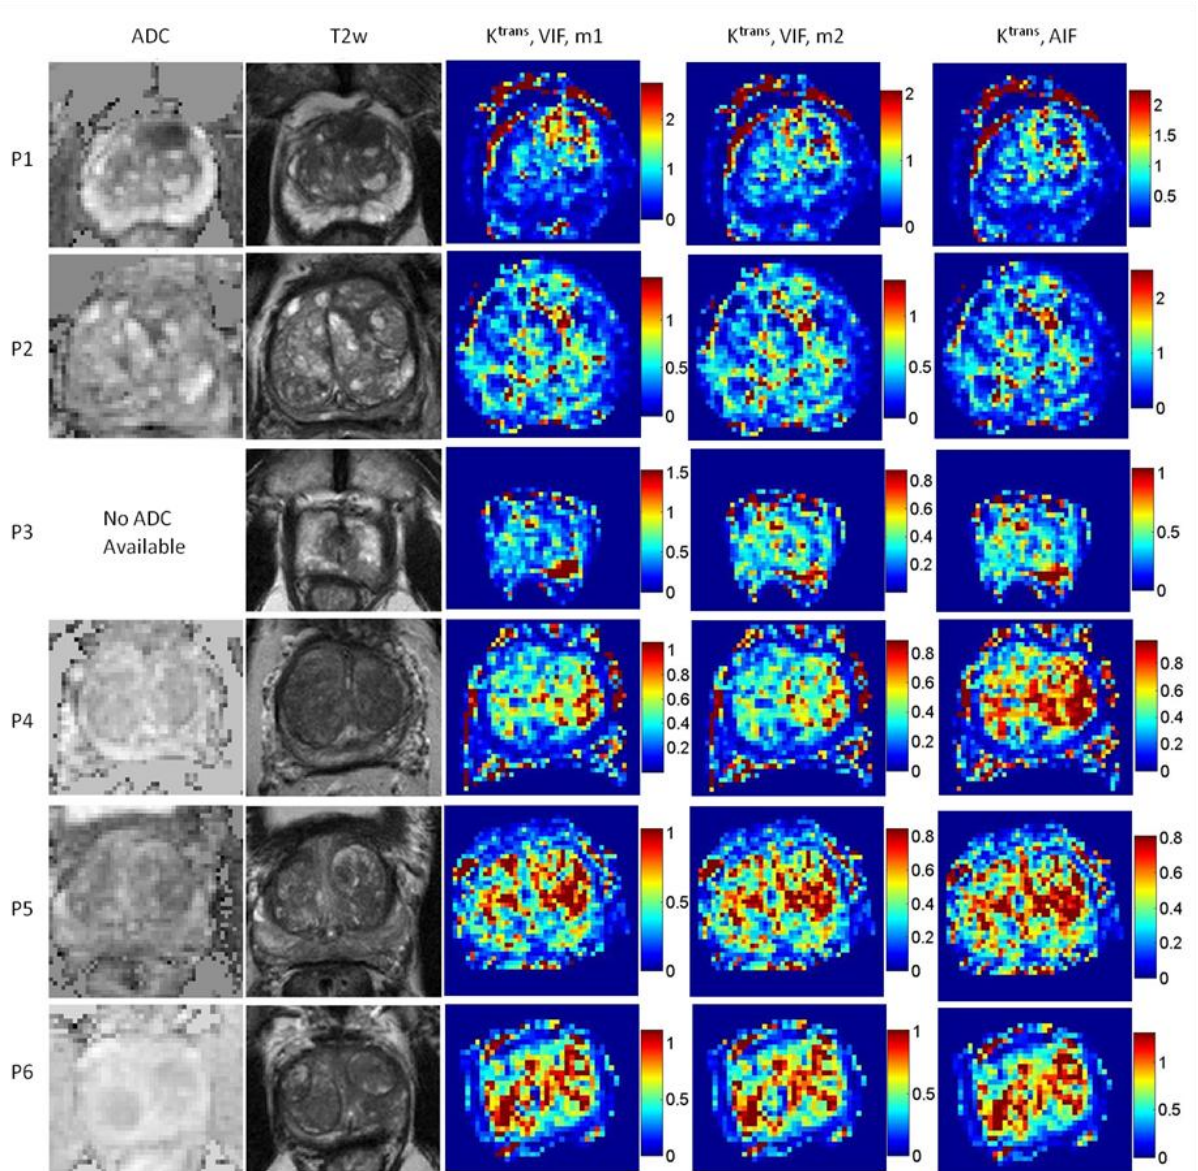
The ADC map (first column), and T_2 -weighted MR image of the slices that were shown in Figure 5-5 which were used for tumor detection. The corresponding K^{trans} maps calculated for extended Tofts-Kety model using the normalized VIF and using ICA-derived v_p map (third column), the normalized VIF and fitting for all 3 PK parameters of extended Tofts-Kety model (fourth column), and normalized AIF (fifth column).
